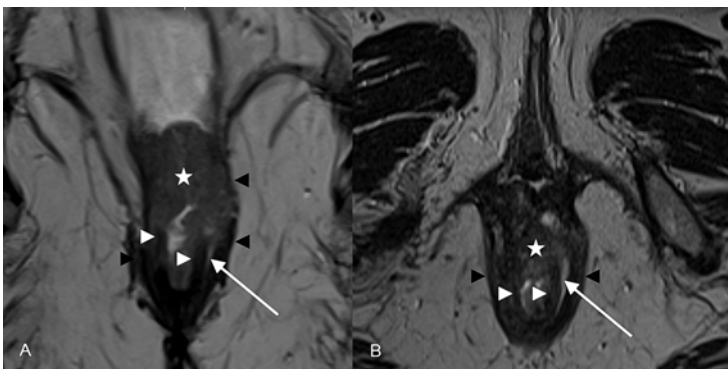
Coronal (a) and axial (b) T2-weighted MR images showing a stage 4 low rectal tumor (white star) with extension into the IAS (white arrow heads), intersphincteric space (white arrows), and the EAS (black arrow heads)
